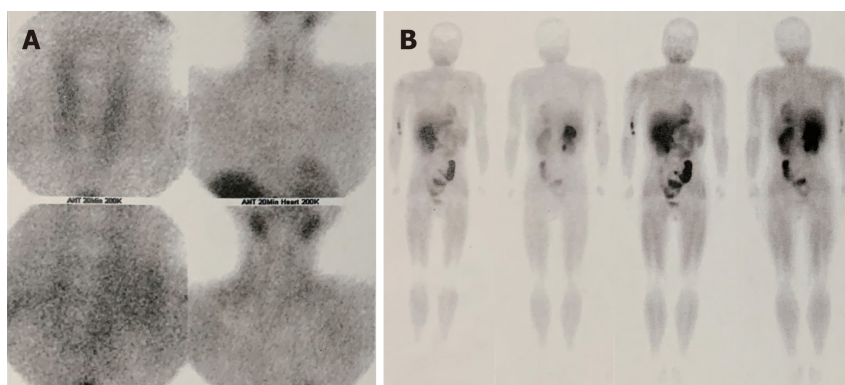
Ultrasound of parathyroid revealed no abnormal changes in the region of parathyroids, nor in ^{99m}Tc -methoxyisobutyl isonitrile imaging. A-B showed that there was no abnormality of parathyroid in ^{99m}Tc -methoxyisobutyl isonitrile imaging, nor any other abnormal radioactivity concentrations.
